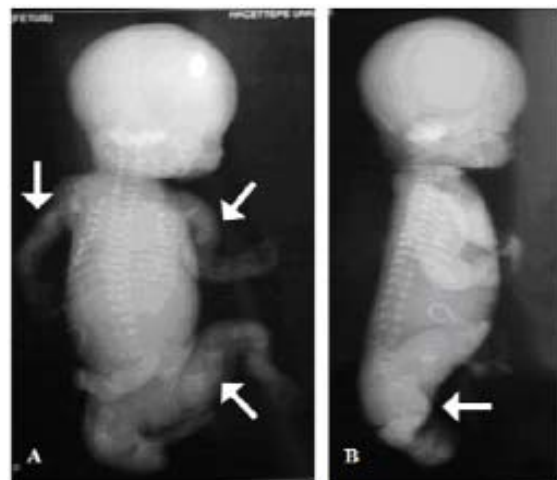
and Figure 2: Antero-posterior and lateral plain x-ray graphs of the fetus
